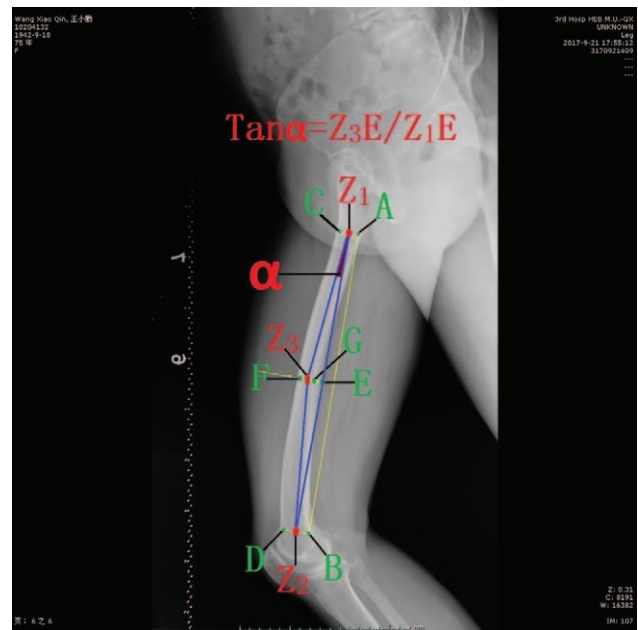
Measurement of lateral femur X-ray image using Digimzer software. The mapping process was as follows: Point A: The posterior inner cortex, lower edge of the lesser trochanter. Point B: The posterior inner cortex and a starting point of the femoral condyle. Point C: Draw a vertical line for AB through A, called line a. Point C is the intersection of line a and the anterior inner cortex. Point D: Draw a vertical line for AB through B, named line b. Point D is the intersection of line b and the anterior inner cortex. Z_1 : Middle point of line AC. Z_2 : Middle point of line BD. E: Middle point of Z_1Z_2 . Point F: Draw a vertical line of AB through E, named line c. Point F is the intersection of line c and the anterior inner cortex. Point G: The intersection of line c and the posterior inner cortex. Z_3 : Middle point of FG. $\tan \alpha = Z_3E/Z_1E$.
